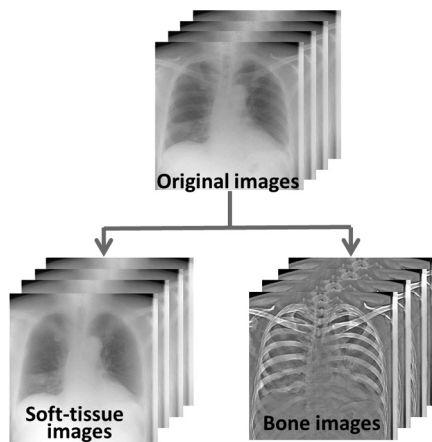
Dynamic soft tissue and bone images generated from dynamic chest radiographs based on the bone suppression technique.
